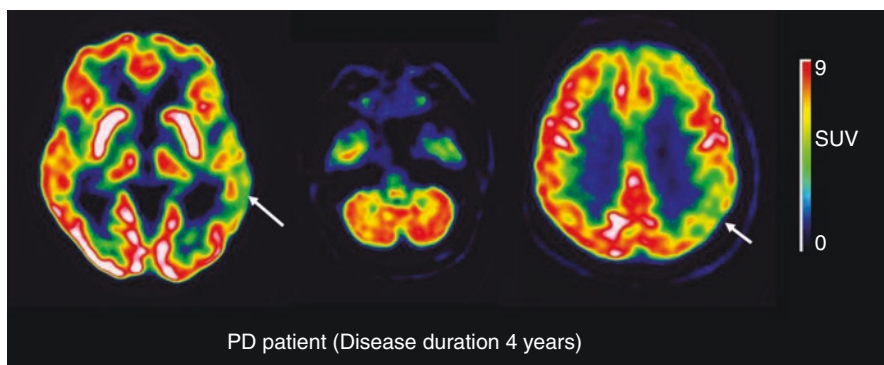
FDG-PET images from a representative Parkinson's disease patients, showing decreased metabolism in the parietal and occipital cortex (arrows). Courtesy of Dr. Stelvio Sestini Nuclear Medicine Unit, Azienda Unità Sanitaria Locale 4, Prato, Italy
